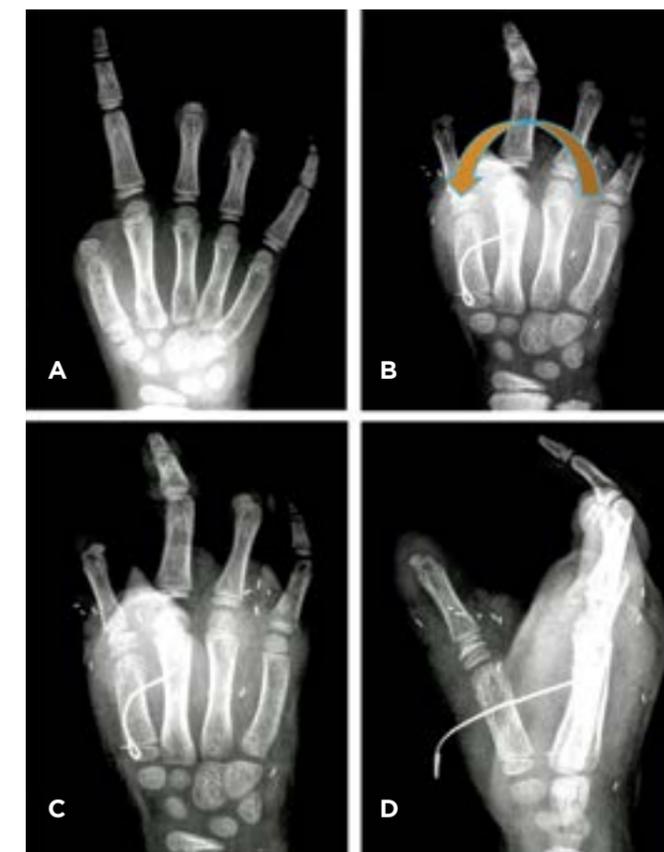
A: preoperative X-ray. B: Principle of transfer of the ring finger on top of the first metacarpal. C,D,E: Early postoperative X-Rays and clinical result. E. Now the child can grasp the glass with one hand and write easily (courtesy Wiebke Huelsemann, Children's Hospital Wilhelmstift, Hamburg).
